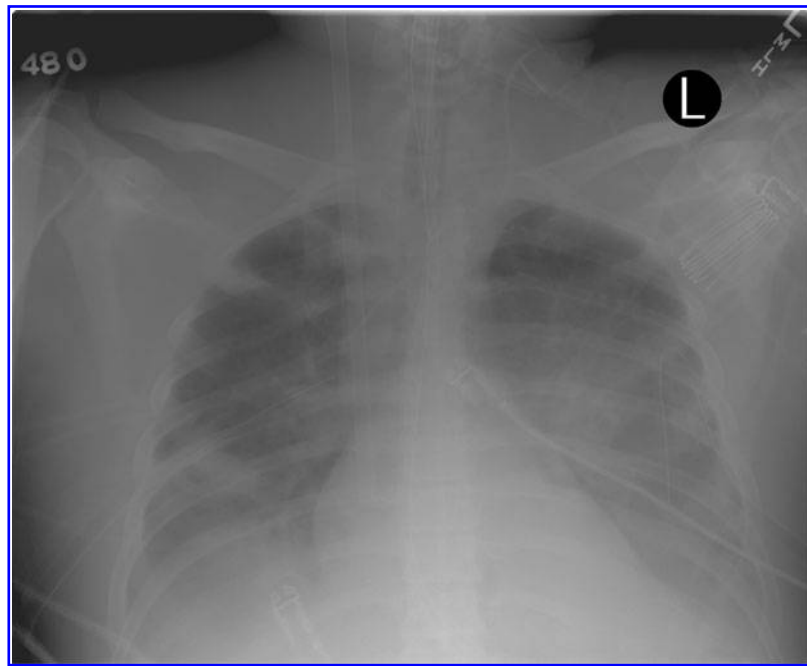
Chest radiograph after cannulation for venovenous extracorporeal membrane oxygenation demonstrating bilateral infiltrates consistent with acute respiratory distress syndrome or bilateral pneumonia.
